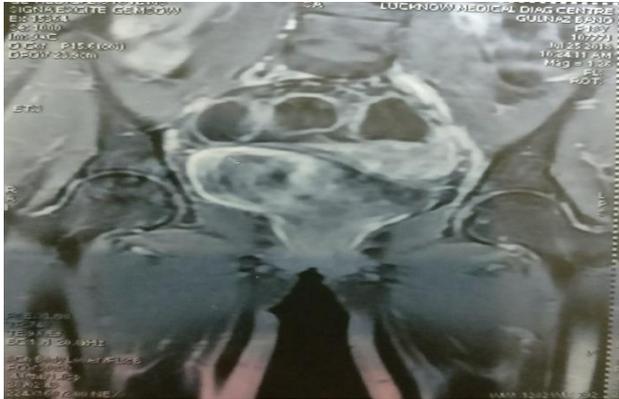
Post RT, MRI pelvis with contrast showing no obvious residual or recurrent lesion.
